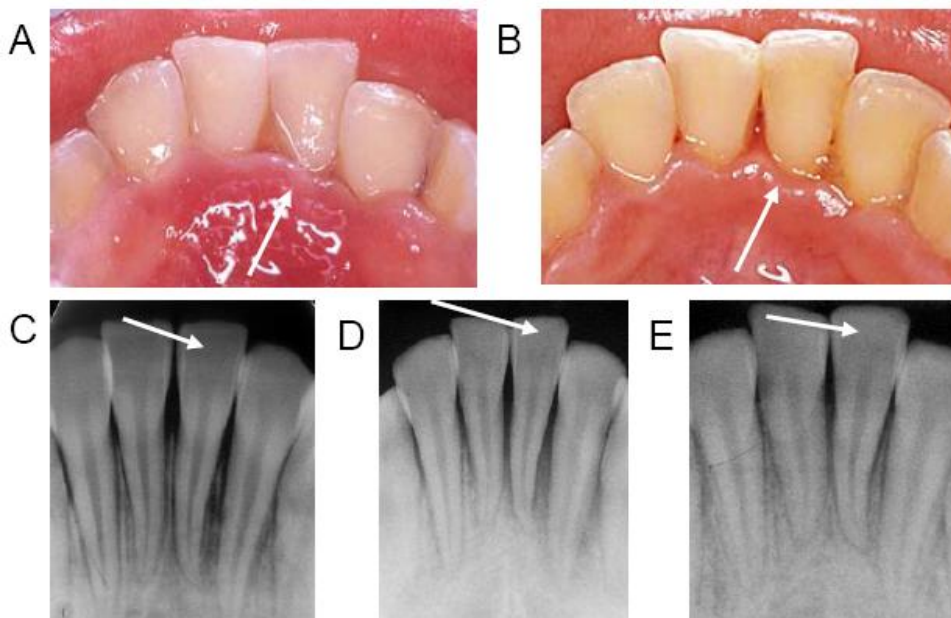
A case of “acute periodontitis.” Intraoral photographs taken at first examination (A) and at the time when the lesion became stabilized (B). Periapical radiographs taken at the first examination (C), 2 weeks (D) as well as 4 months (E) after the first examination. Arrows indicate the affected tooth.
